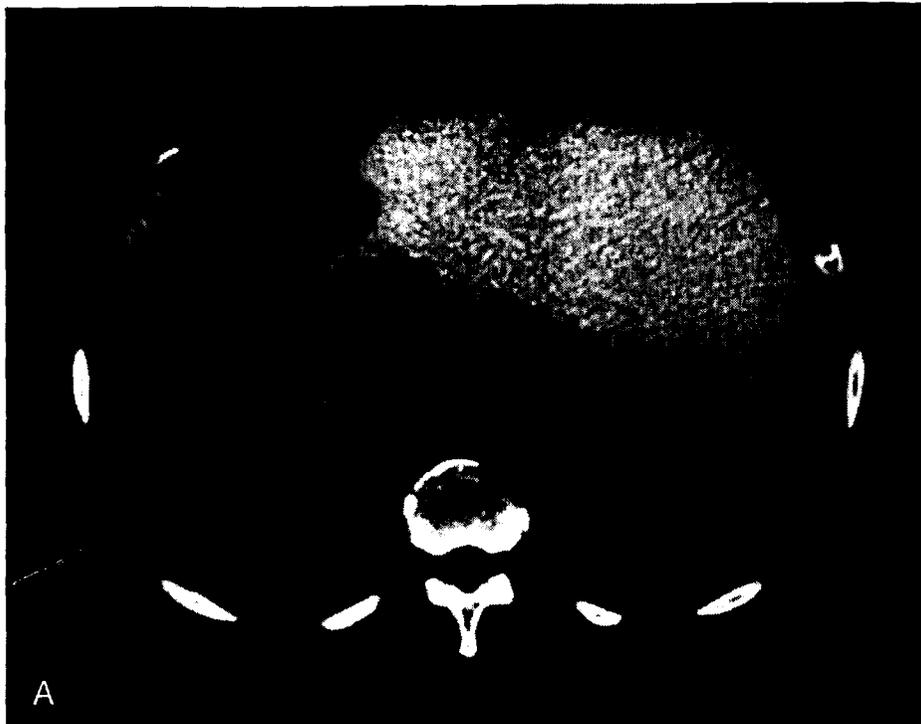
Palliation of gastric carcinoma with a Wallstent Enteral in 69-year-old man in whom gastric carcinoma had been diagnosed after complaints of early satiety and a 50-pound weight loss over 4 months. *A*, His CT scan showed a circumferential mass lesion in the antrum. The patient underwent stenting after an exploratory laparotomy showed that the tumor extended into the pancreas. He underwent venting gastrostomy and feeding jejunostomy surgery. Stent placement was however requested to allow peroral feeding. *B*, The stent (22 mm in diameter and 90 mm in length) was placed through the malignant stenosis over guidewire.
